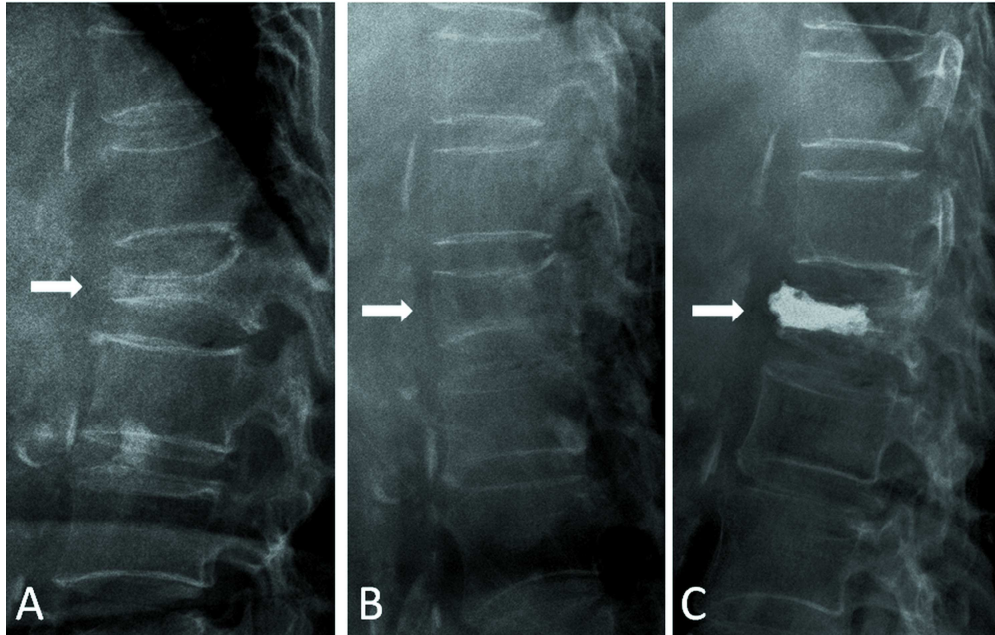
A 62 year-old woman suffered from severe back pain due to T12 compression fracture. The anterior vertebral body height in sitting (A) lateral radiograph is 7.23 mm, changed to 21.22 mm in supine with bolster (B) lateral radiograph, and 15.41 mm in post-vertebroplasty radiograph. 190x120mm (400 x 400 DPI)
